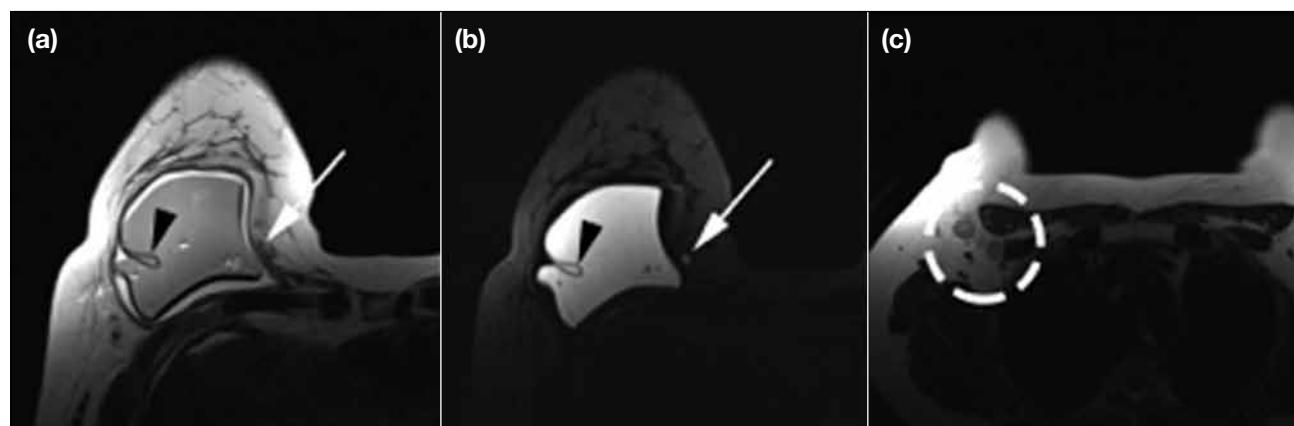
A 42-year-old woman presenting with hardening of a right breast silicone implant. (a) Axial T2-weighted magnetic resonance imaging (a) turbo spin echo scan, (b) scan with fat and water suppression, and (c) turbo spin echo scan at a higher level than (a). Right intra-capsular rupture is seen with presence of 'tear-drop sign' (arrowheads). The small focus (arrows) of hyperintense signal on water suppression image (b), with signal intensity parallel to the silicone implant at the medial aspect is indicative of extra-capsular silicone and therefore extra-capsular rupture. (c) Prominent level I axillary lymph nodes (dotted circle) are present, likely reactive and related to underlying intra- and extra-capsular implant rupture.
